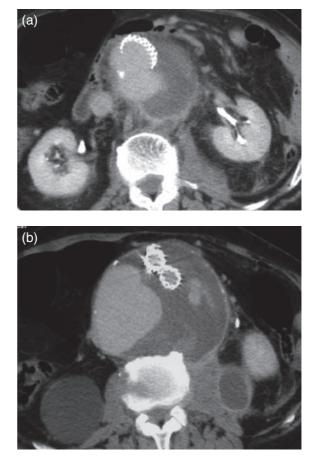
(a) CT scan demonstrating type I endoleak. (b) Type I endoleak and posterolateral aneurysm rupture.
